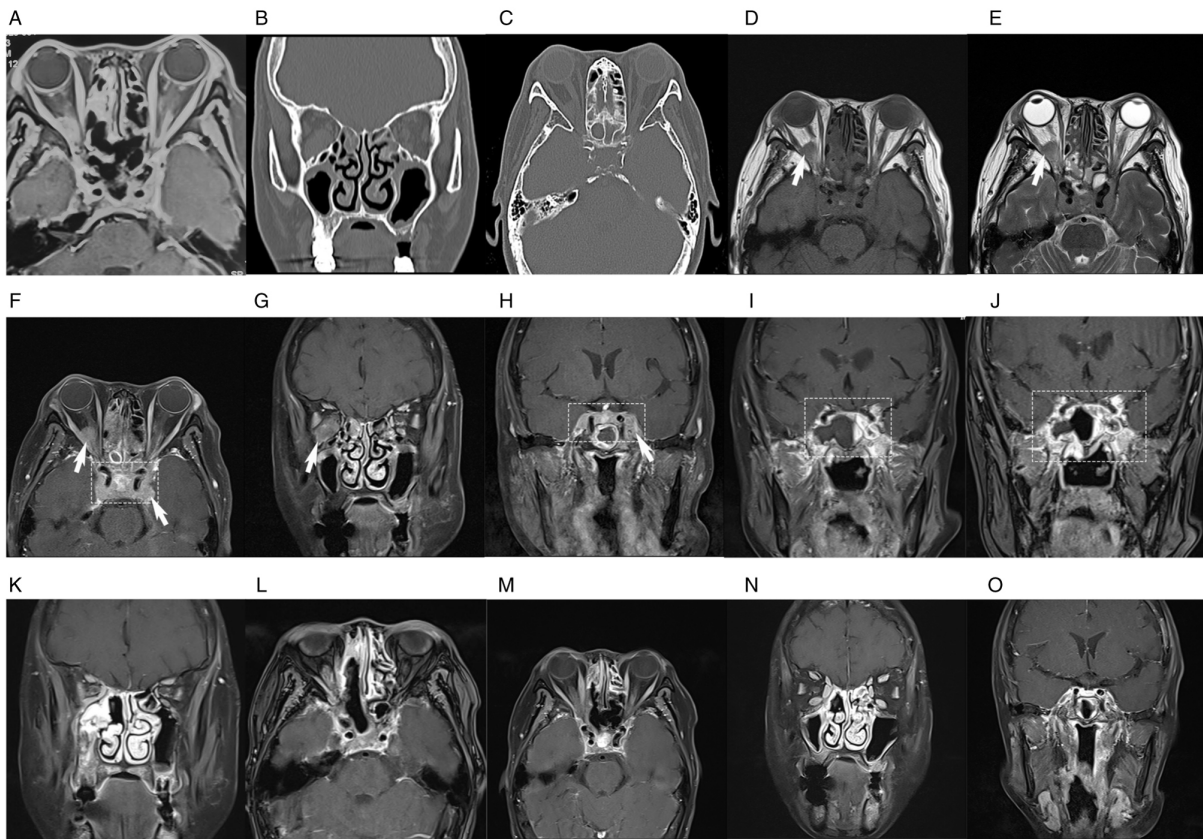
MRI findings and CT scan images of the patient. (A) MRI of patient at the first visit. (B) Coronal CT scan of the skull base, orbit and sinuses at the first visit. (C) Axial CT scans of the skull base, orbit and sinuses at the first visit. (D-H) Baseline MRI before initiation of the R-CHOP regimen. (D) Axial T1-weighted imaging showing a 1.2x1.6x0.9-cm lesion at the right orbital apex (white arrow). (E) Axial T2-weighted imaging. (F) Axial and (G) coronal T1 fat-suppressed gadolinium-enhanced MRI images demonstrating masses located in the right intraconal orbital space (white arrow), left intraorbital optic nerve sheaths, nasal cavity, paranasal sinuses and bilateral CSs (rectangular marquee). (H) Coronal contrast-enhanced MRI of the bilateral CSs (rectangular marquee). (I) MRI of bilateral CSs after 3 cycles of R-CHOP combined with a BTK inhibitor. (J) MRI revealing an enlarged CS lesion after 4 cycles of R-CHOP combined with a BTK inhibitor compared with that after 3 cycles of the regimen (rectangular marquee). (K) Coronal contrast-enhanced MRI of skull base, orbit and sinuses after six cycles of R-CHOP combined with BTK inhibitor and two courses of HD-MTX. (L) Axial contrast-enhanced MRI of the CS, orbit and sinuses after 6 cycles of the regimen. (M) Axial contrast-enhanced MRI of the CS, orbit and sinuses post-treatment corresponding to images F before treatment. (N) Coronal contrast-enhanced MRI of the orbit and sinuses post-treatment corresponding to images G before treatment. (O) Coronal contrast-enhanced MRI of the CS post-treatment corresponding to images H before treatment. After treatment, marked regression of the lesions in the CSs and the right orbit was observed. MRI, magnetic resonance imaging; CT, computed tomography; CS, cavernous sinus; BTK, Bruton tyrosine kinase; HD-MTX, high-dose methotrexate; R-CHOP, rituximab, cyclophosphamide, doxorubicin, vincristine and prednisolone.
